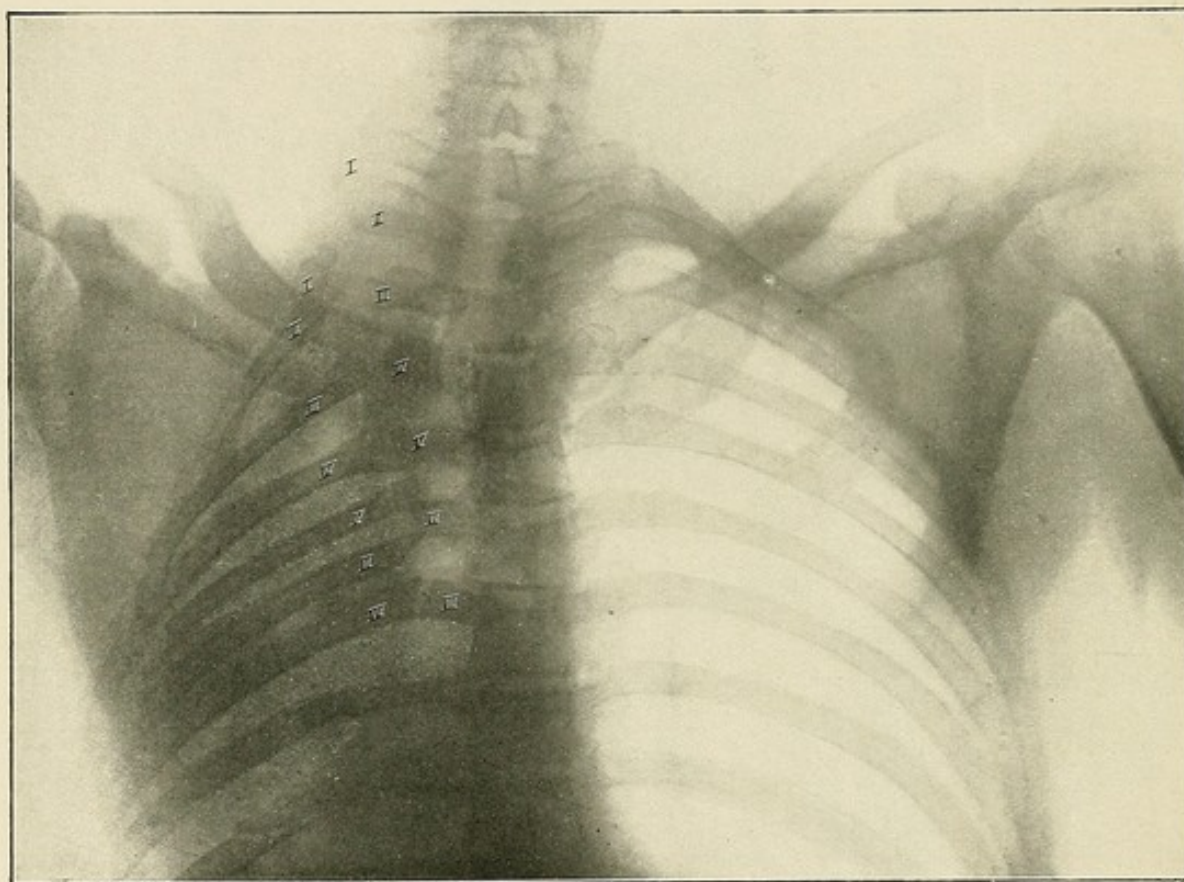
X-ray picture of the patient of fig. 67 (1st to 6th rib bent right down and inwards. Cavity between the 3rd and 4th rib reduced by one-half, pronounced retraction of lung).
